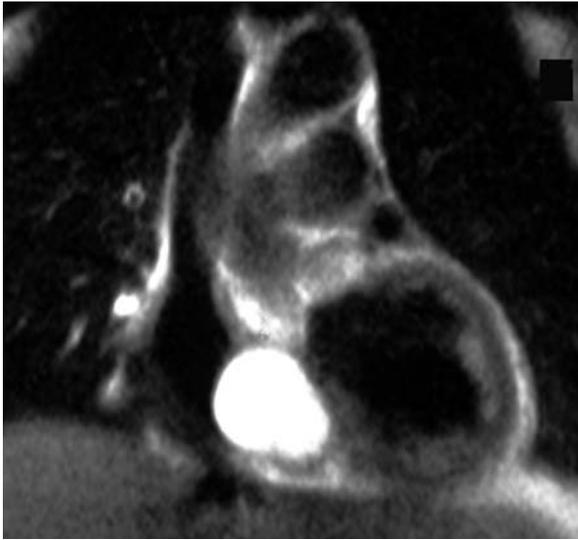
Cardiac bronchogenic cyst. Coronal T2-weighted TSE image shows a well-defined hyperintense mass in the interatrial septum. Surgical resection revealed a bronchogenic cyst
